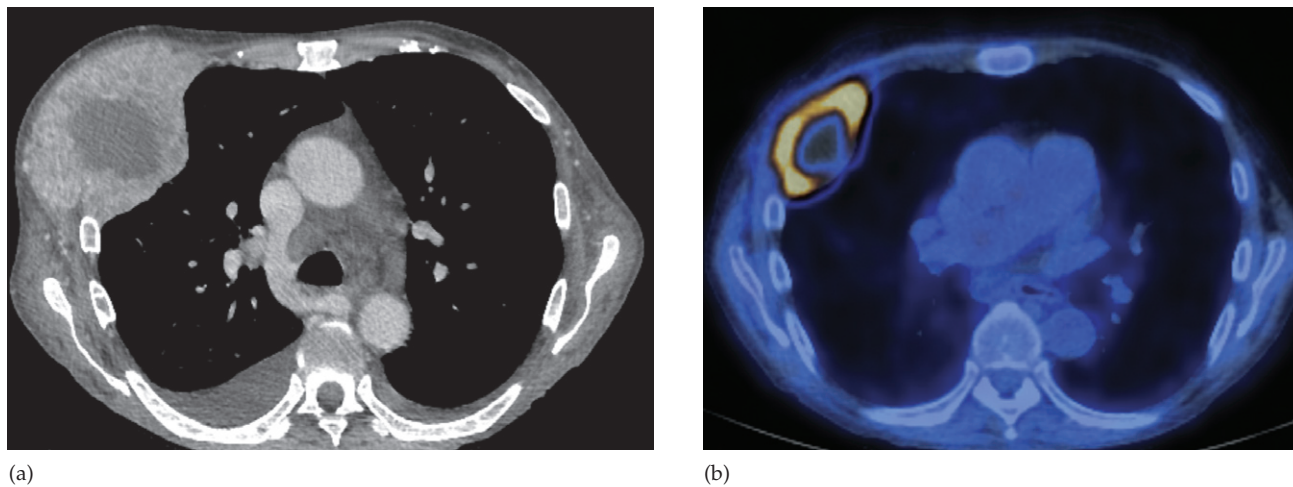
(a) CT in a patient with metastatic renal cancer, and (b) FDG-PET/CT in a different patient, demonstrating a large focal pleural deposit.
